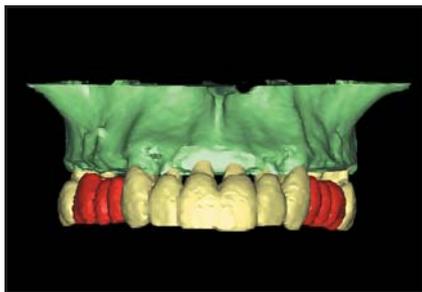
Masks can be incorporated on 3D CT reconstructions to enable the isolation of structures for specialized viewing. Here, masks of the maxilla, natural teeth, and proposed implant prostheses are observed. Proposed final tooth positions are highlighted in red.
